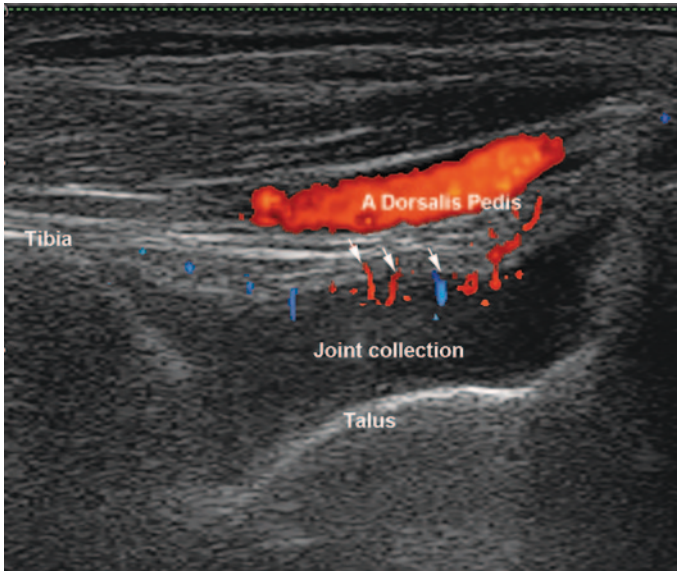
Longitudinal view of the anterior recess of the tibiotalar joint with the Doppler box on. A hypoechoic joint collection is seen inside the joint. Above it, the dorsalis pedis artery crosses the image. Below the vessel reverberation Doppler artifacts (*arrows*) seem like Doppler signal inside the collection. The top of the Doppler box is at the top of the image
